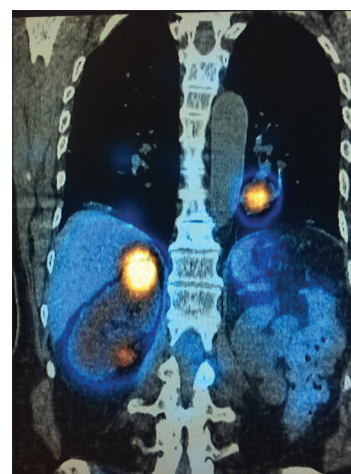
Follow-up single photon emission computed tomography/computed tomography imaging with indium-111-labeled octreotide demonstrates progression of metastatic disease, with two octreotide avid metastatic tumor deposits in the (contralateral) right kidney, which developed 2 years subsequently. An octreotide avid pulmonary metastasis is noted in the left lung
